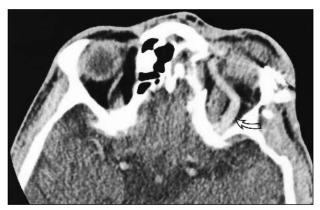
Enhanced axial CT demonstrates marked left orbital swelling and proptosis, transfixed fractures and massive left superior ophthalmic vein (SOV) (arrow).
